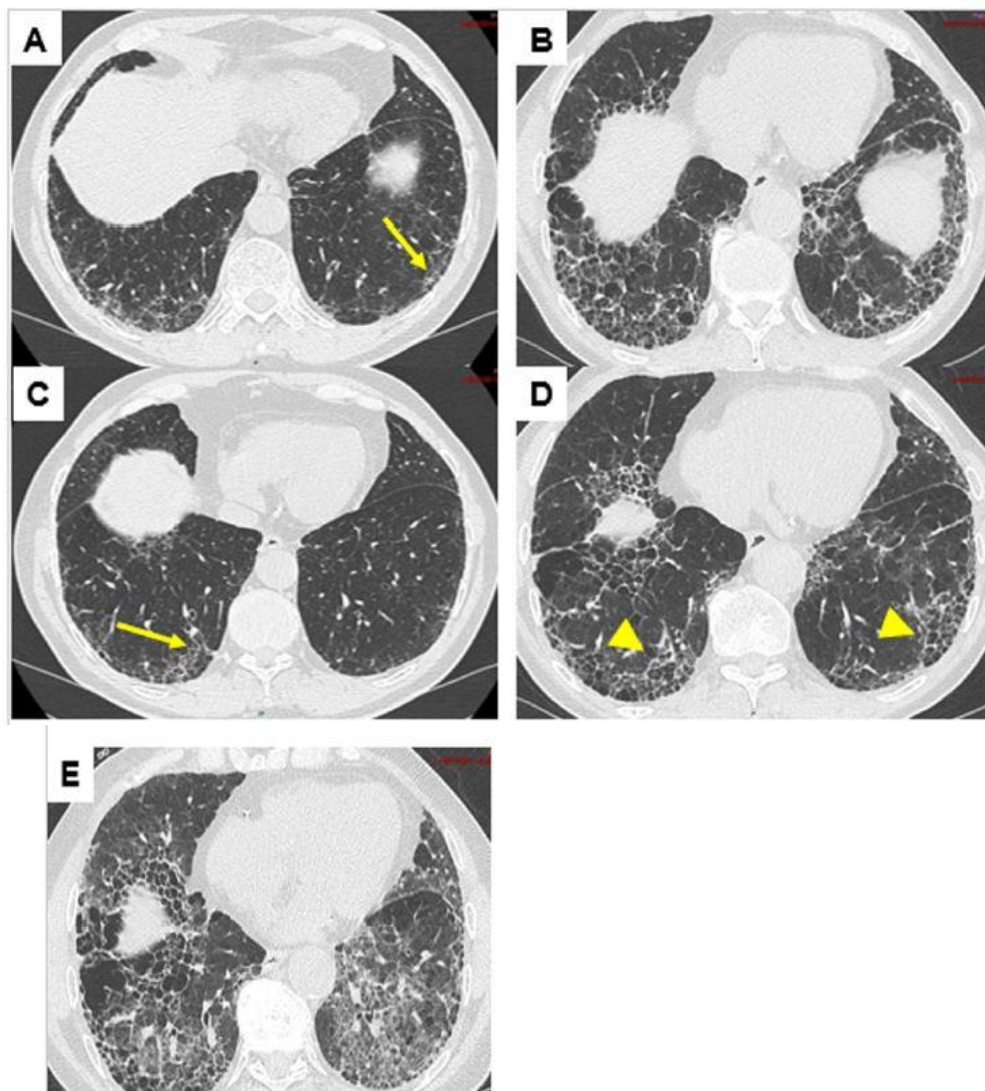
Usual interstitial pneumonia (UIP) pattern on the chest CT scan. A, C: probable UIP pattern, with predominantly subpleural and basal reticular opacities, traction bronchiolectasis (arrows), in the absence of any sign incompatible with this diagnosis. B, D: UIP pattern on the follow-up CT scan, with predominantly subpleural and basal reticular opacities, honeycombing (arrowheads), traction bronchiectasis, in the absence of any sign incompatible with this diagnosis. E: chest CT scan performed at the time of an acute exacerbation of fibrosis, showing a ground-glass appearance in addition to pre-existing opacities.
